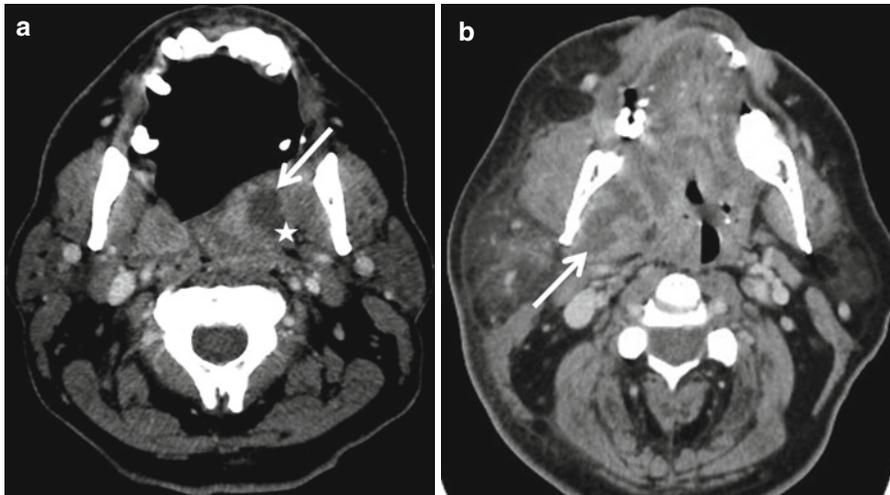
Peritonsillar abscess. Axial contrast-enhanced CT shows low-density irregular left peritonsillar abscess (*white arrow* in a) with extension in the left parapharyngeal space (*star*). The right tonsil demonstrates mildly striated enhancement, which is suggestive for inflammation. Another case (b) shows extension from the right masticator space (*arrows*) due to right mandibular periodontal disease
